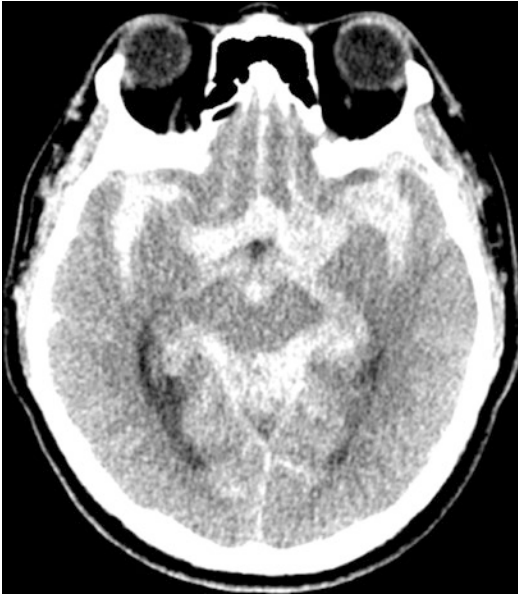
Typical diagnostic image of SAH on CT is a hyperattenuating material seen filling the subarachnoid space, most commonly apparent around the circle of Willis and extending to sulci, fissures, and ventricles
